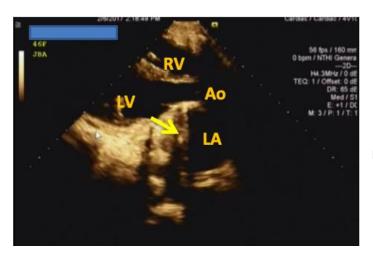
Post-operative 2D echocardiography:
